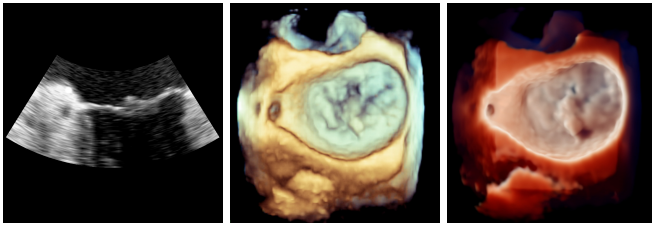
Comparison of ultrasound image renderings of a mitral valve. (Left) Conventional B-mode. (Center) Standard 3D. (Right) Photo-realistic image that evokes natural vision, making interpretation of the scene more fluid.
